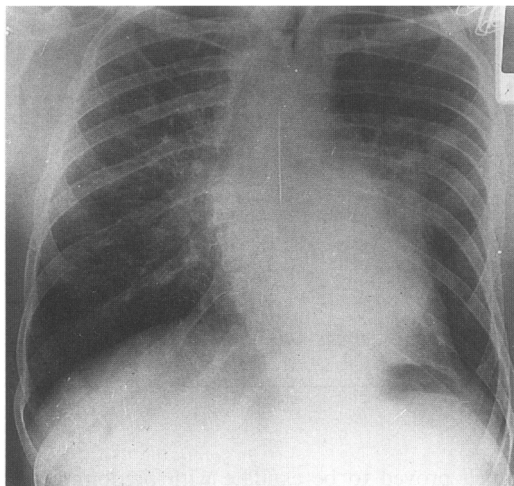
Chest X-ray showing a shadow in the left mid zone.
